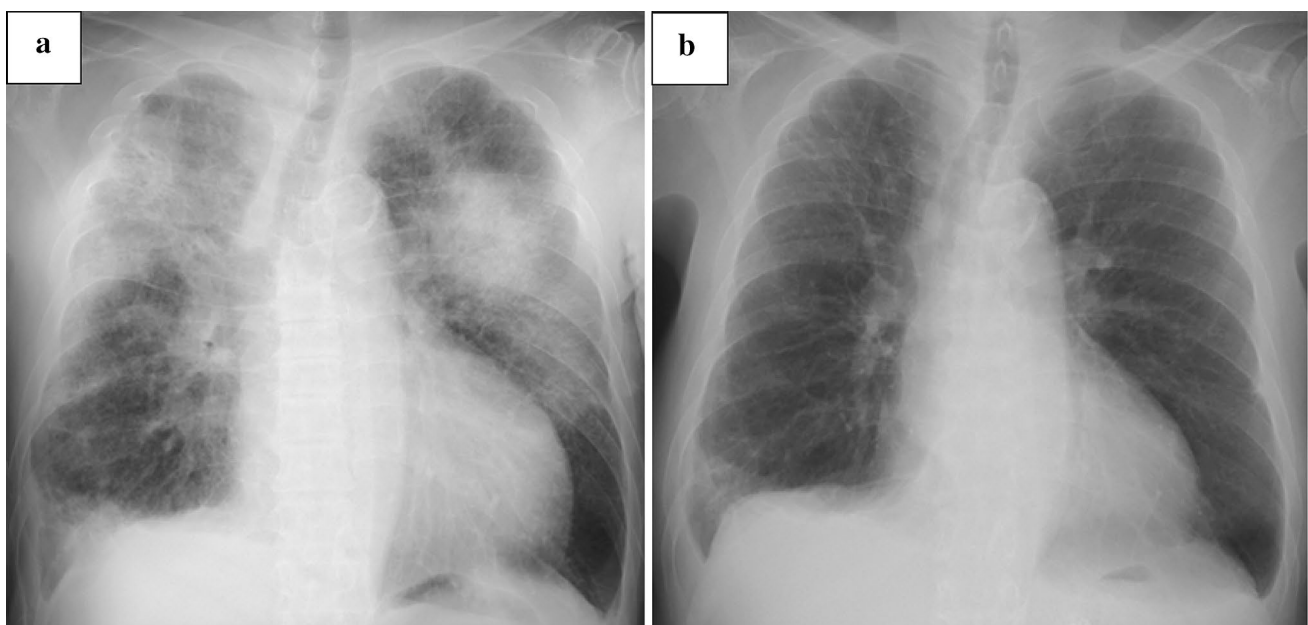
Chest X-ray findings. a On admission. b At discharge
